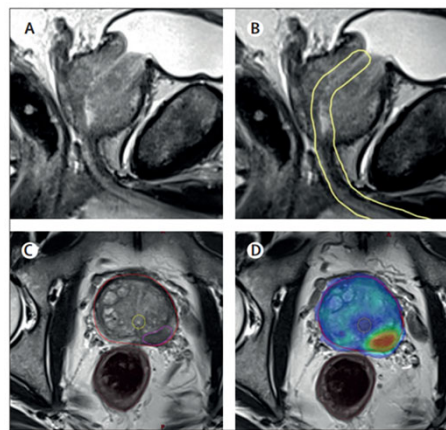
Urethral-sparing radiotherapy on a series of T2-weighted MRI slices
